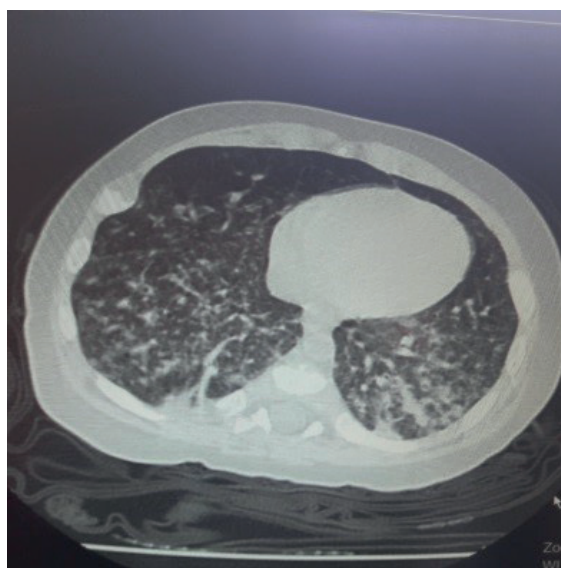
Thorax CT revealed peripheral atelectasis and consolidation areas.
